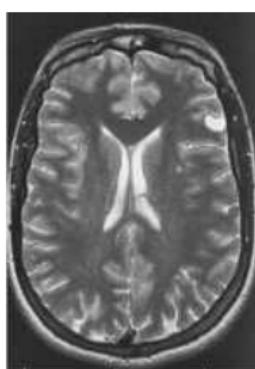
MRI of cysticercus in left fronto-parietal cortex of a 35yr-old woman who presented with focal seizures. A cystericus was also visible under the skin of her left wrist. Both lesions disappeared after 4wks of albendazole treatment.
